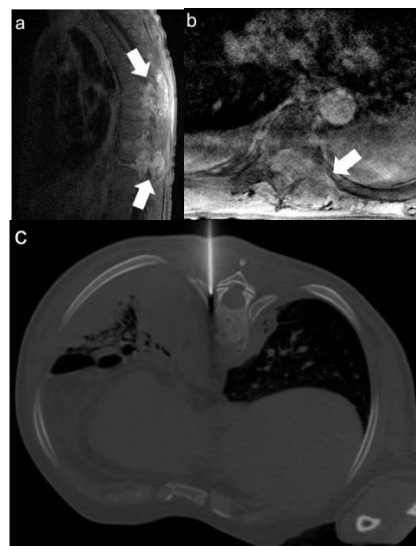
Sagittal (a) and axial (b) postcontrast fat-suppressed T1-weighted magnetic resonance images show contrast enhancement at two different levels (arrows). The same patient underwent computed tomography-guided percutaneous biopsy (c)
